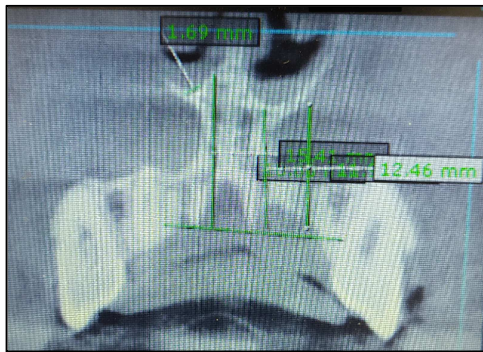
Bone height & width measured on CBCT
